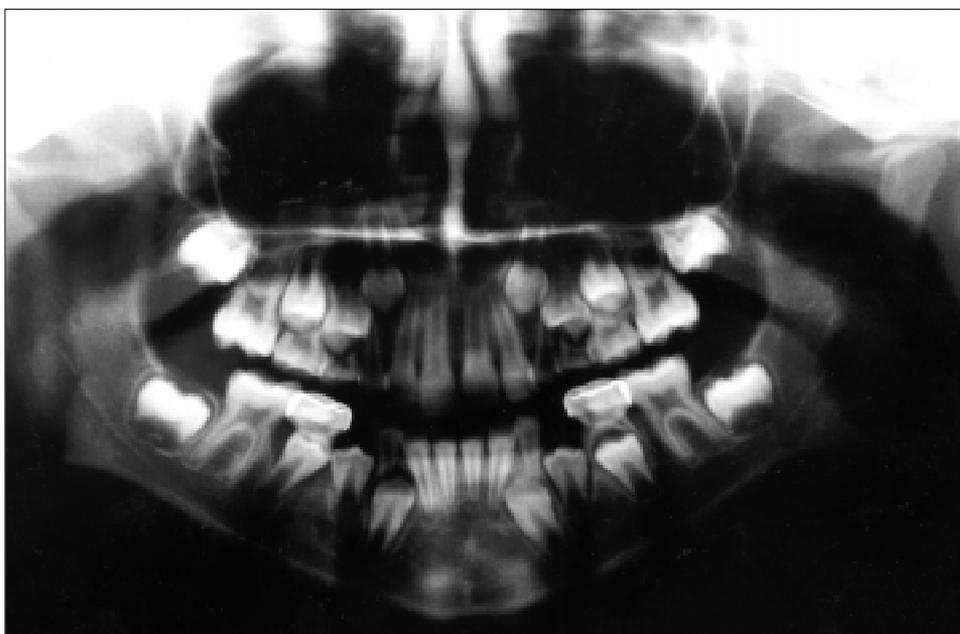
Orthopantomograph of a patient aged 7 years with Dystrophic Epidermolysis Bullosa.
